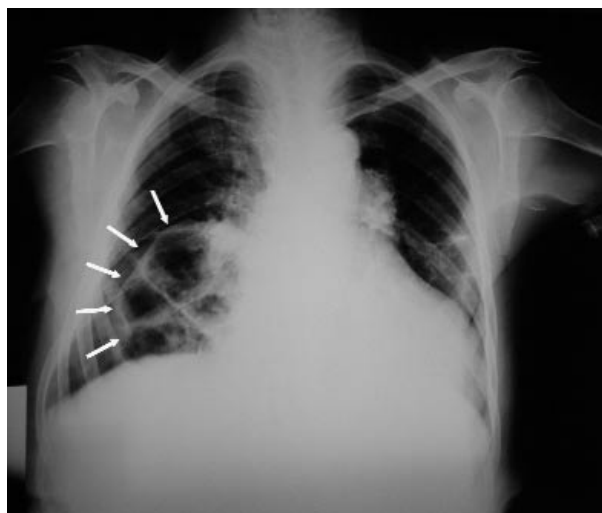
Anteroposterior chest X-ray.
